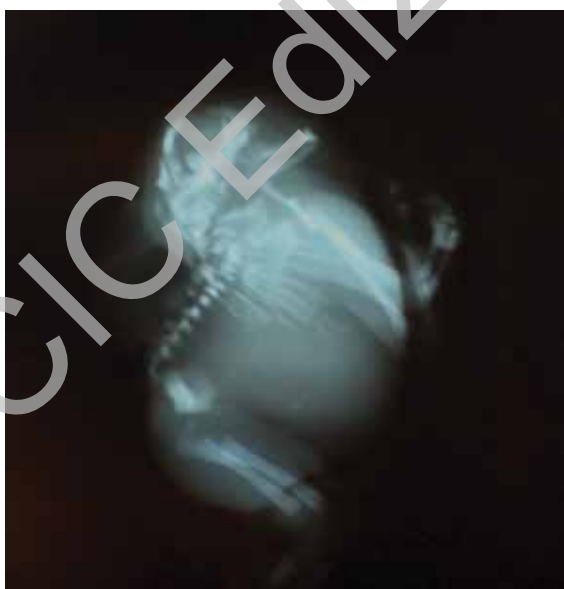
Ultrasonographic image of the fetus with posterior mediastinal unilocular anechoic cyst.
